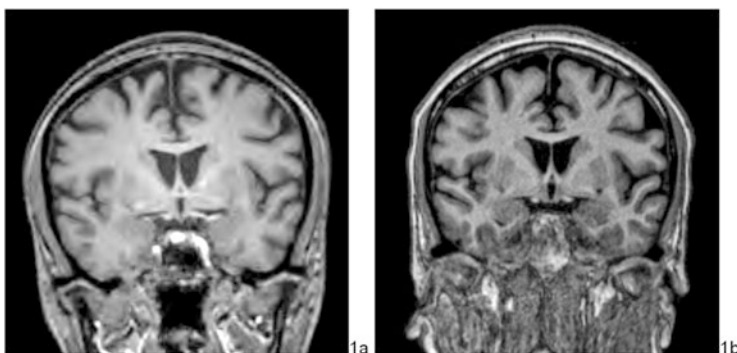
(a and b) MRI performed in 2015 (a) and in 2016 (b)
